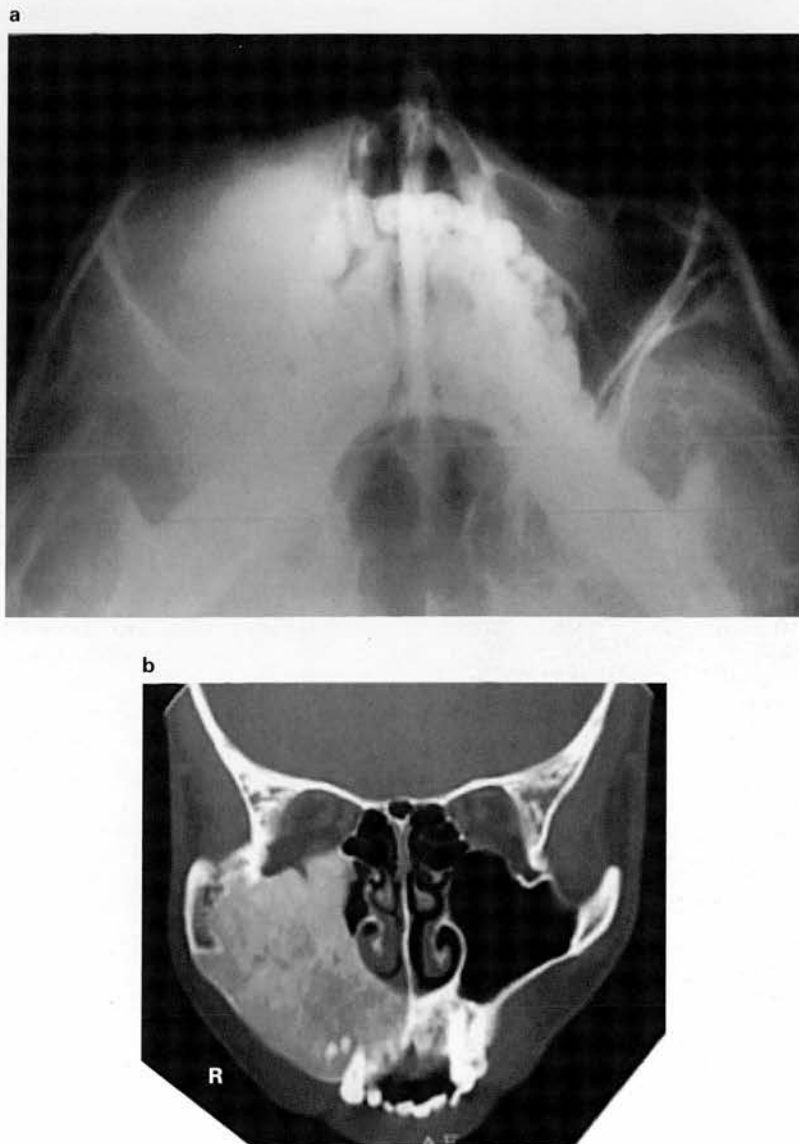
(a) (Case 4) An occipitomental projection exhibiting an extensive radiopacity with a 'ground-glass' appearance in the right maxillary antrum. Note the expansion of the right lateral and medial walls and the orbital floor. (b) (Case 4) A bone-window coronal CT scan confirming not only the substantial enlargement of the right side of the face but also almost complete obliteration of the lumen of the right maxillary antrum and inferior meatus. There is an upward displacement of part of the orbital floor. In many places the cortex is thin or absent. The alveolar process is also expanded buccolingually
